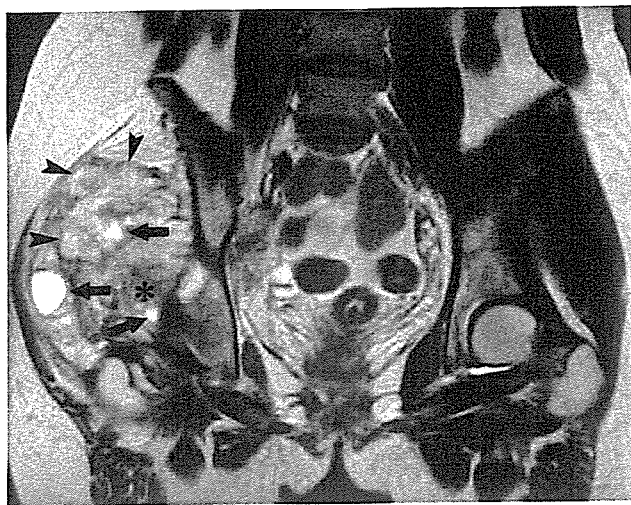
A 19-year-old woman with synovial sarcoma (high-grade) in right buttock. A, Coronal T2-weighted fast spin-echo (3500/100) MR image demonstrates triple signal pattern that includes high signal similar to that of fluid (arrows), intermediate signal intensity equal to or slightly hyperintense relative to fat (arrowheads), and low signal intensity closer to that of fibrous tissue (asterisk).
